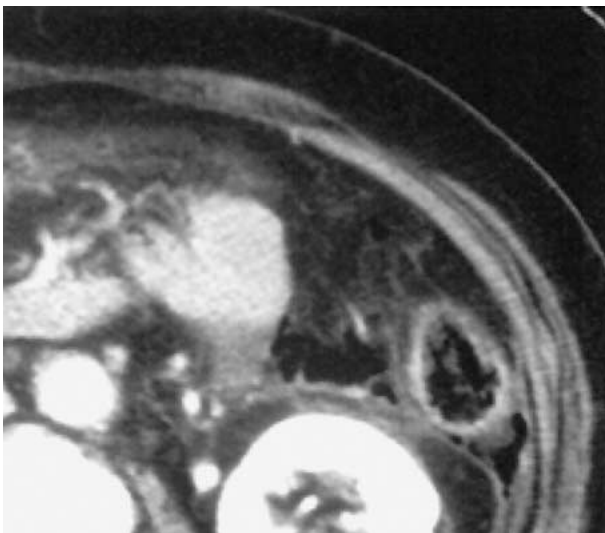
CT image at the level of the left kidney in a patient with a rupture of the sigmoid colon. Pneumoretroperitoneum is observed in the anterior pararenal space.
